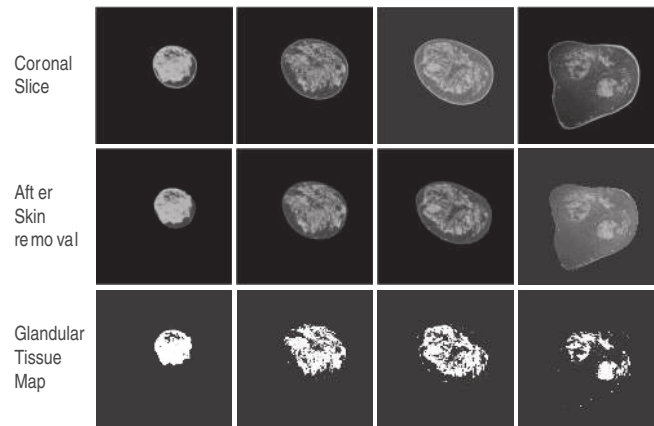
Four slices selected from a single breast CT volume are shown. The top row contains the coronal slices, the middle row shows the corresponding slices after segmenting and removing the skin, and the bottom row shows the binary maps corresponding to the slices generated using KFCM, where the region representing fibroglandular tissue have a value of 1.
